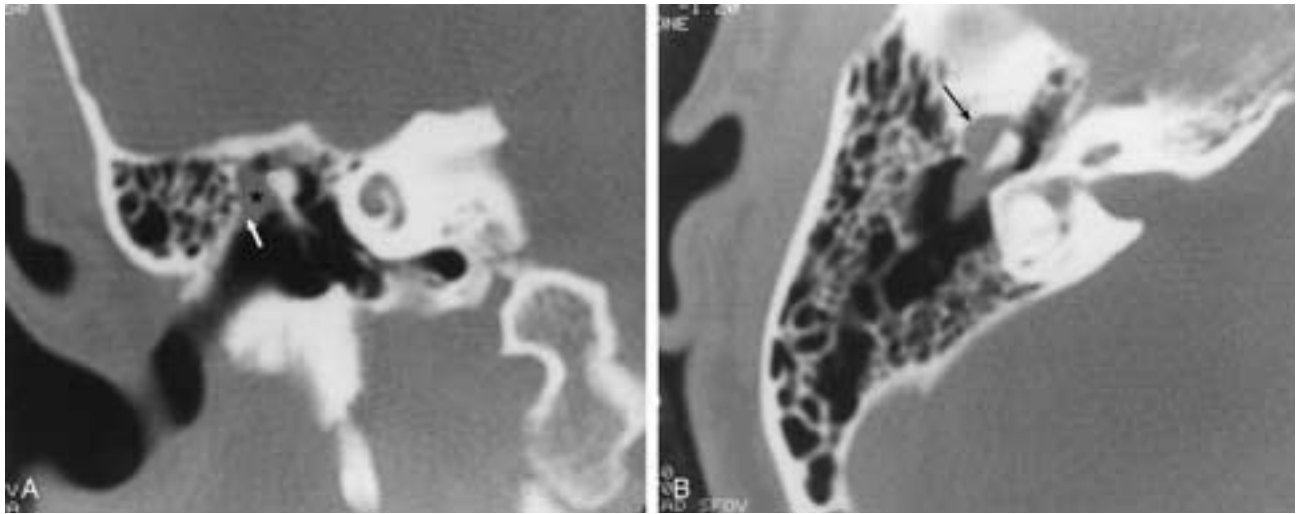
Acquired cholesteatoma, Prussak's space. A, Coronal CT image demonstrates a soft-tissue mass (*asterisk*) interposed between the lateral attic wall and the malleus head. Note the blunted scutum (*arrow*). B, Axial CT image again demonstrates a soft-tissue mass with remodeling of the lateral attic wall (*arrow*). The mass extends posteriorly through the aditus into the mastoid antrum.
